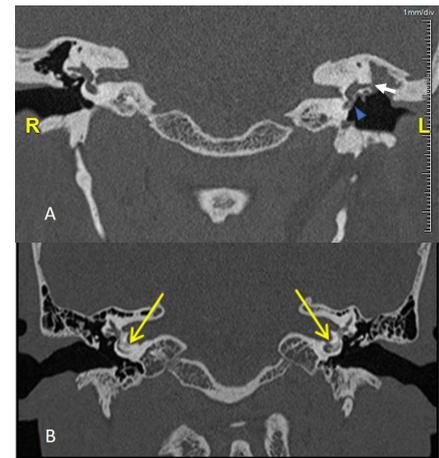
(A) Coronal HRCT temporal bone reveals erosion of the left tail of the Mermaid representing promontory (arrow head) and focal erosion of the lower hand of the Mermaid representing the lateral semicircular canal (LCC) (white arrow). (B) Coronal image of HRCT temporal bone reveals bone deposition in the bilateral Mermaid tails representing deposition in bilateral basal turn of cochlea (arrow) suggestive of labyrinthitis ossificans.
